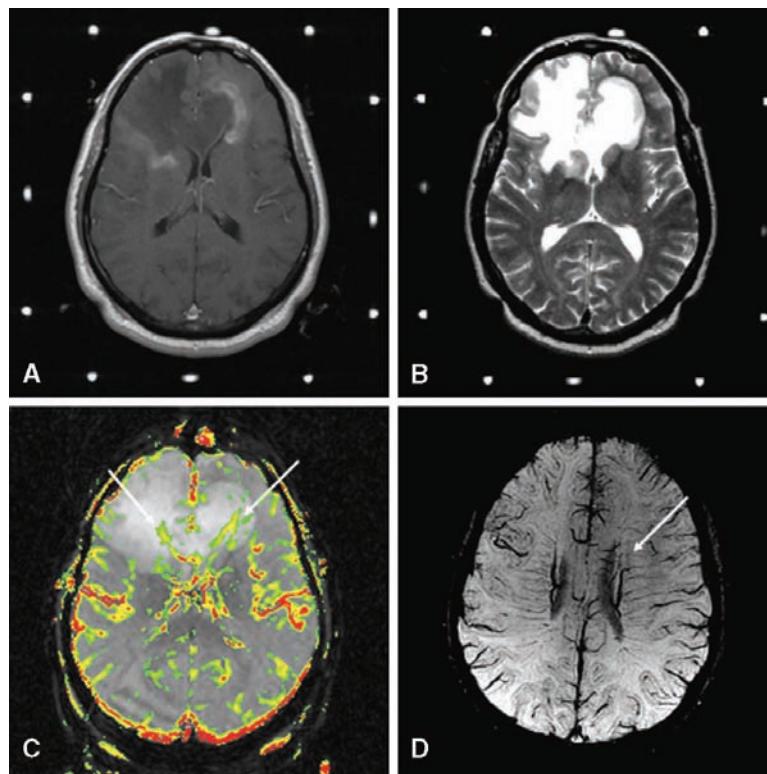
A 57-year-old man with a TDL. (A) Axial T1-weighted image postgadolinium in the stereotactic headframe shows a peripherally enhancing mass in the frontal regions with involvement of the corpus callosum. The mass-like appearance and “butterfly” configuration prompted the neurosurgeon to stereotactic surgical resection. The incomplete ring of enhancement is sometimes seen in TDLs. (B) Axial T2-weighted image demonstrates increased T2 signal within the lesion with minimal edema. (C) Gradient-echo axial DSC MRI with rCBV color overlay demonstrating reduced vascularity within the lesion, even at the enhancing so-called leading edge. Prominent vessel-like structures (veins) are identified within the lesion. These TDLs are known to arise along vascular or venular structures (12,81). (D) (SWI) demonstrates association of these lesions with prominent periventricular venules. Abbreviations: TDL, tumefactive demyelinating lesion; DSC MRI, dynamic susceptibility contrast MRI; rCBV, relative cerebral blood volume; SWI, susceptibility weighted imaging;
